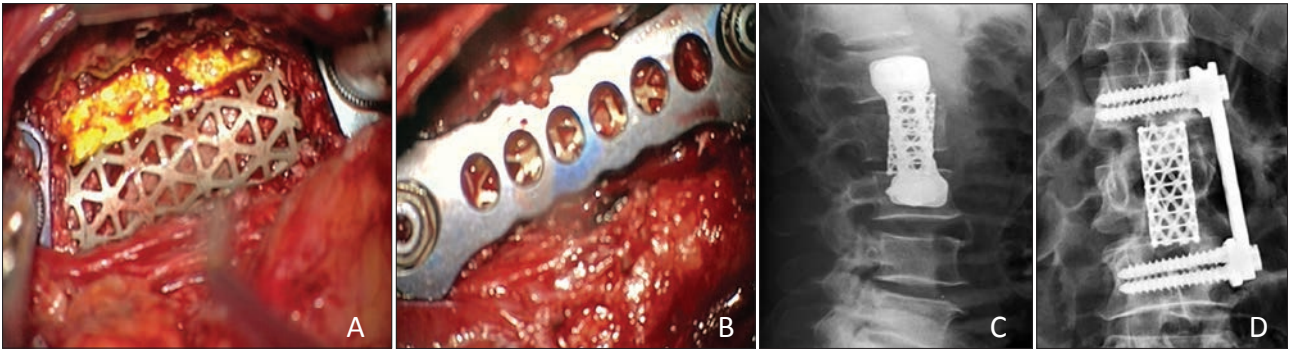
A: operative foto after corpectomy and cage insertion. B: foto after plating. C,D: postoperative AP, lat radiographs.
